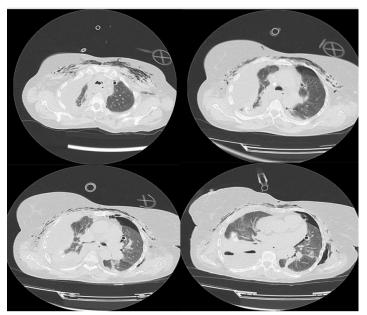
A chest CT of the patient showed mild hydrothorax and pneumothorax on the left side with evidence of contusion in the path of the chest tube tip, severe pleural effusion on the right side in the form of loculated with internal air lucency (pneumothorax), collapse consolidation in the lower lobe (RLL) of the right lung, pericardial effusion, pneumoperitoneum, pneumomediastinum, pneumothorax and subcutaneous emphysema (their value has decreased compared to the previous CT scan (Figure 2,4).
